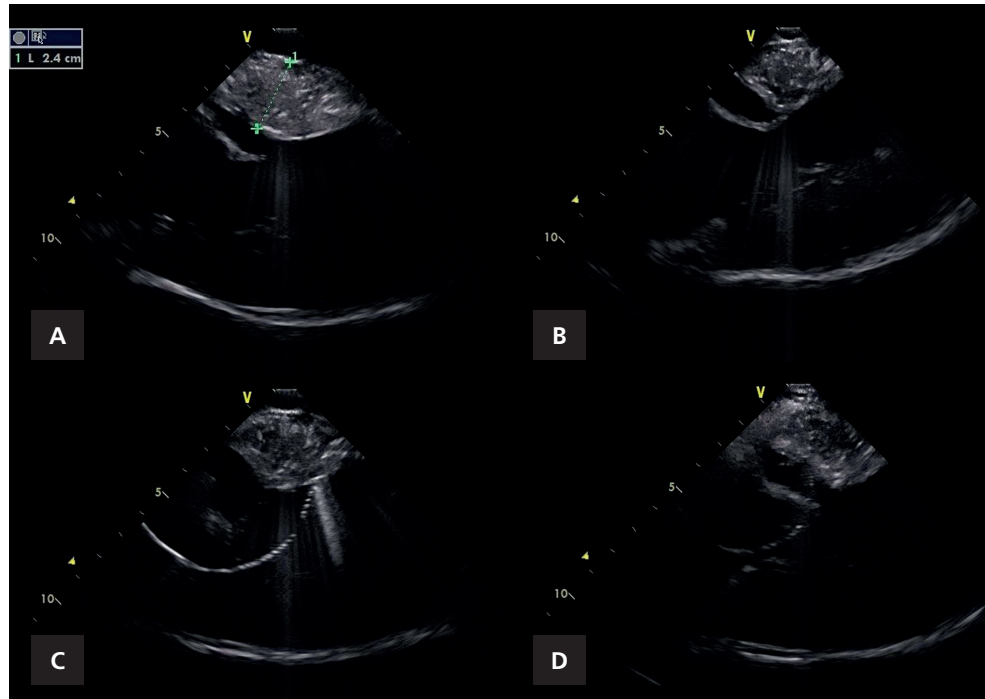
Endocardial radiofrequency ablation of septal hypertrophy, images from intracardiac ultrasound. (A) Hypertrophic septum, (B) contact of catheter with myocardium, (C, D) creating ablation lesions.
